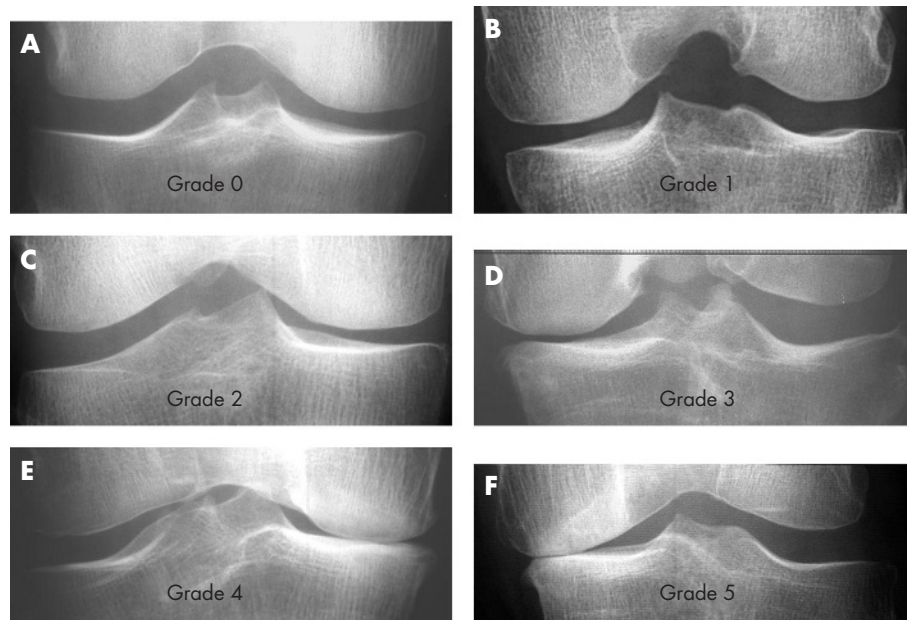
Atlas of radiographs used by the observer for scoring of joint space narrowing.
